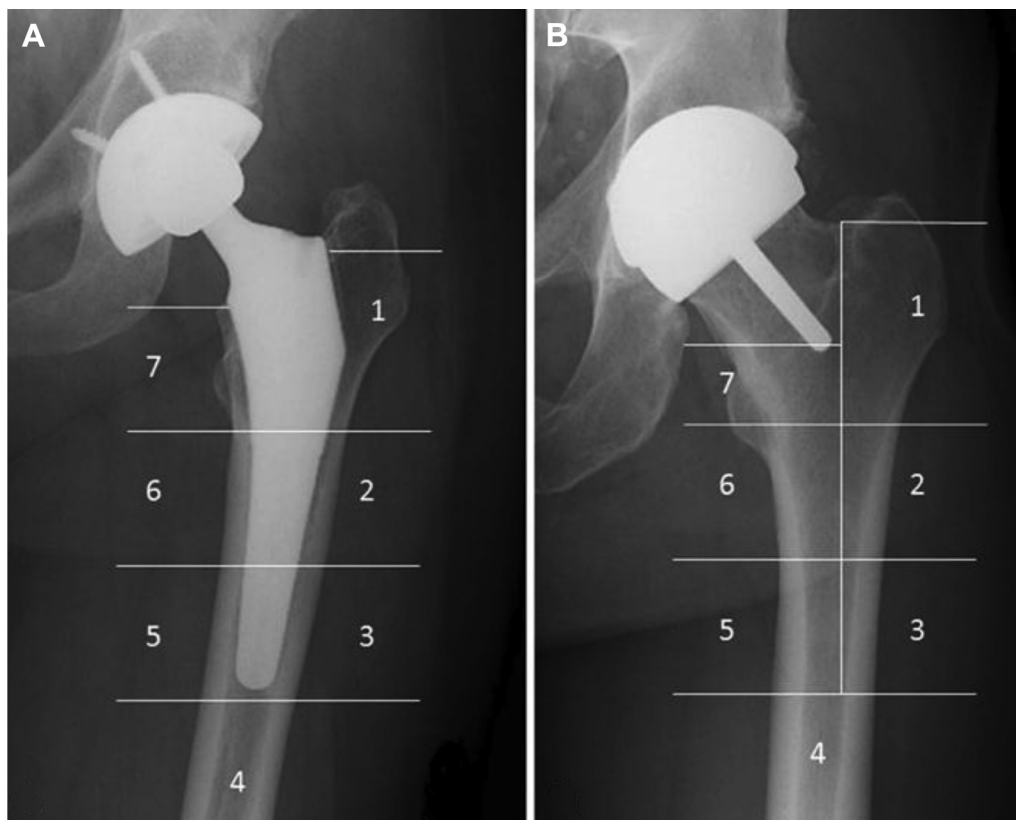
Radiographs demonstrating (A) the 7 Gruen zones in patients undergoing total hip arthroplasty (THA) and (B) the Gruen zone template that was superimposed on the image from a patient undergoing SRA to allow comparison to the 7 Gruen zones in a THA.
